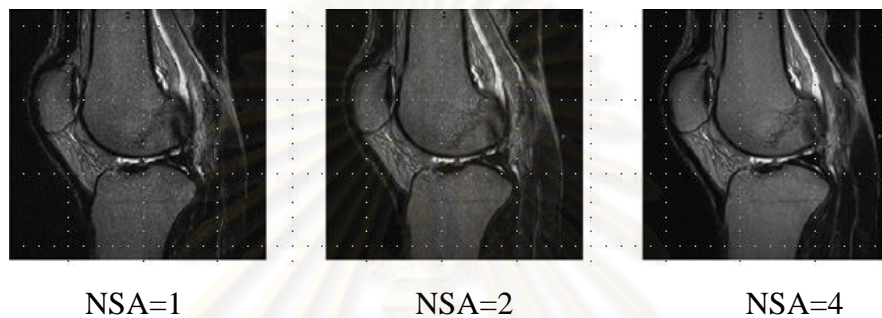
Increasing the NSA the SNR is improved (understanding MRI: Philips)
